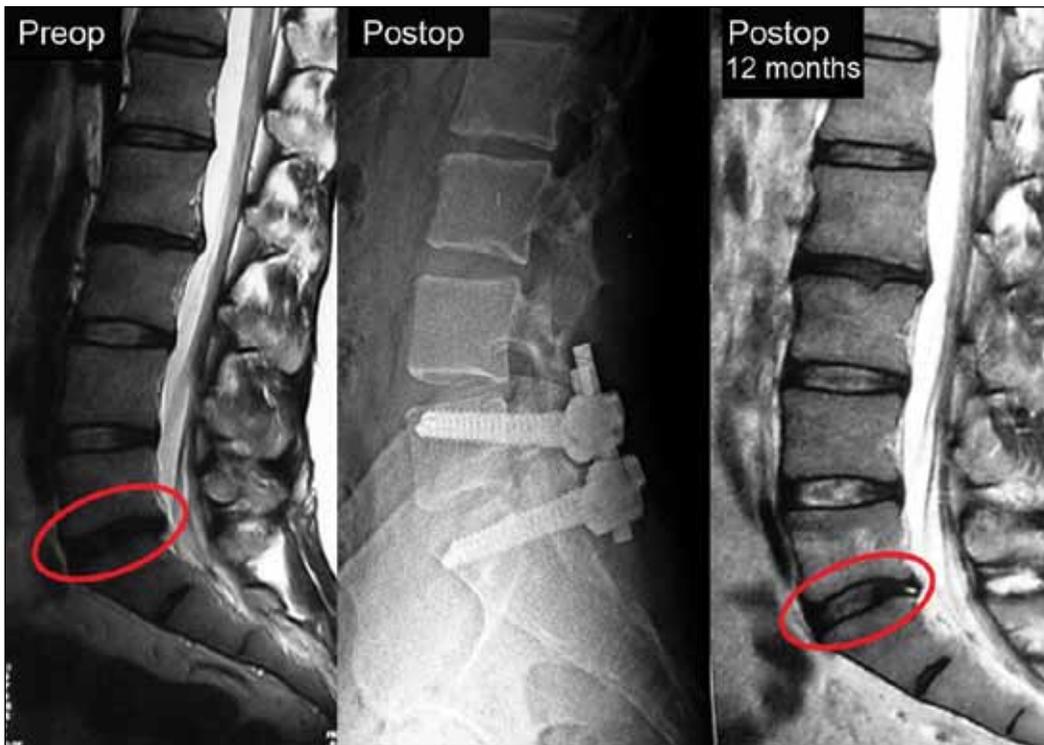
MRI scans show the rehydration and healing of the disc tissue after dynamic posterior instrumentation in a patient with segmental instability.
